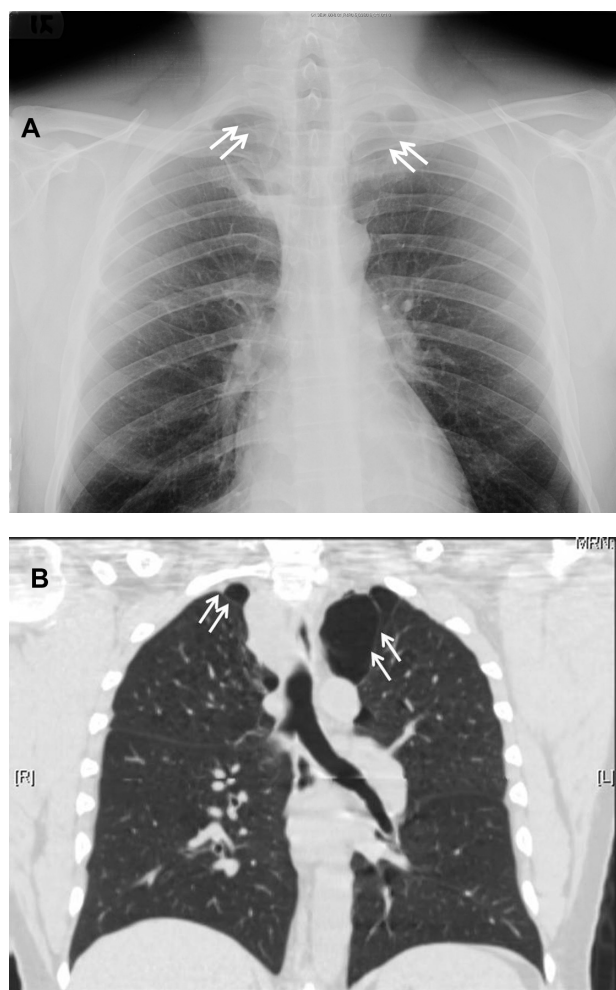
Chest radiograph at 4 month follow-up from admission, the inferior edge of bilateral apical lung bullae has now returned superiorly (double white arrows), indicating the auto collapse of bullae bilaterally (A). Computer tomography confirms the chest radiograph finding (B), lower borders of the bullae have arisen (double white arrows).
